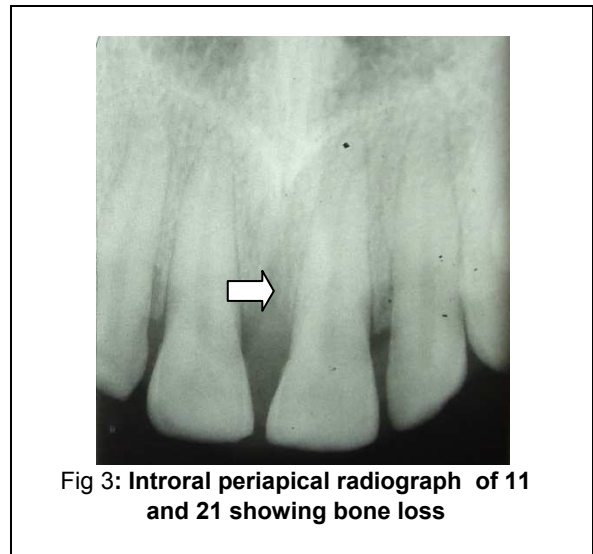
Intraoral periapical radiograph of 11 and 21 showing bone loss
